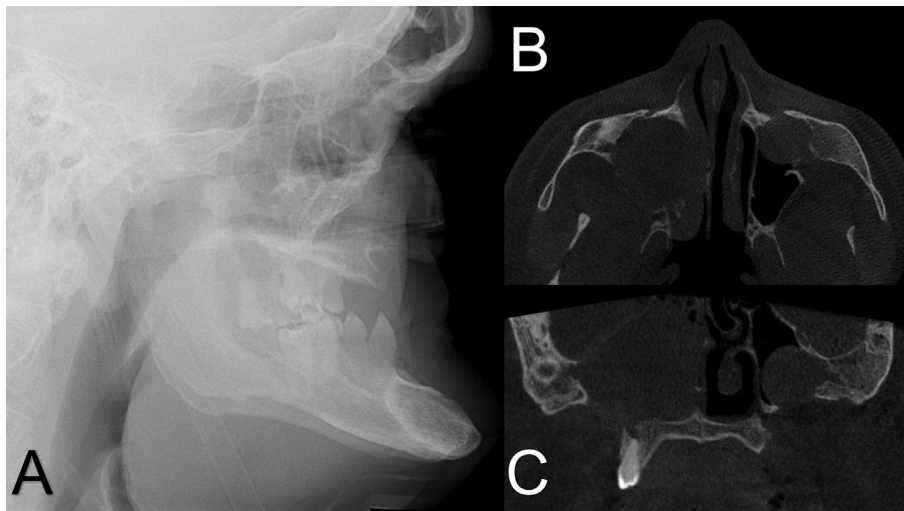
Lateral skull radiograph (A), CBCT axial slice (B) and CBCT coronal slice (C) of a patient with NBCCS. Note the Class III malocclusion and bilateral OKs that are localized bilaterally at maxillary sinuses.
